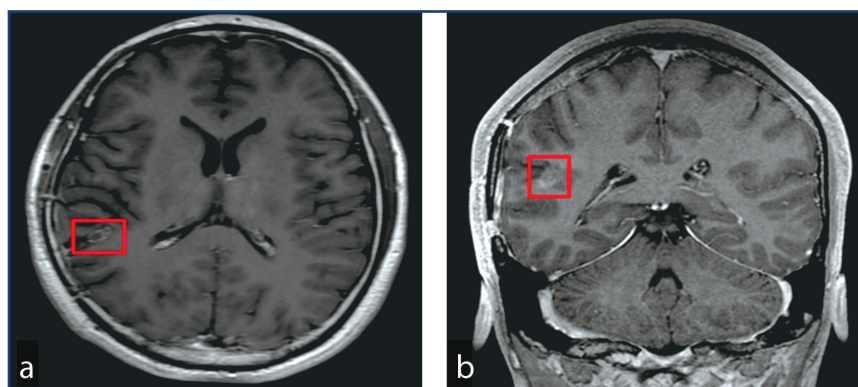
Follow-up brain MRI, 3 months after surgery: a – axial projection, b – frontal projection.
